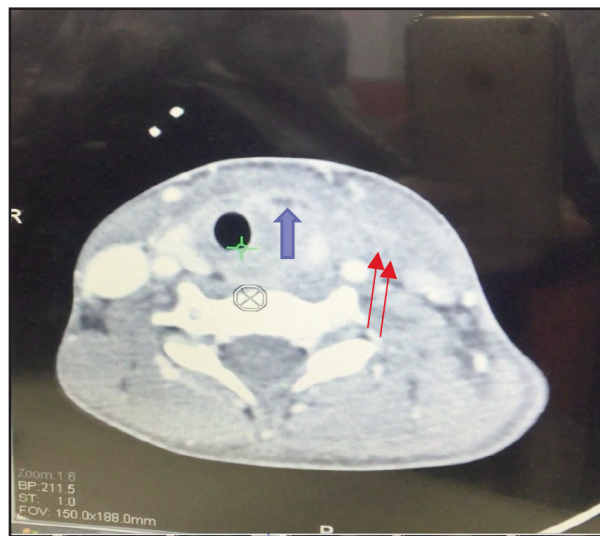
A repeated CT scan of the neck showing compressed thrombus in the left internal jugular vein (blue arrow) with multi-loculated abscess measuring 2.1 x 1.9 x 2.5 cm (red arrow). Trachea is displaced to the right.
